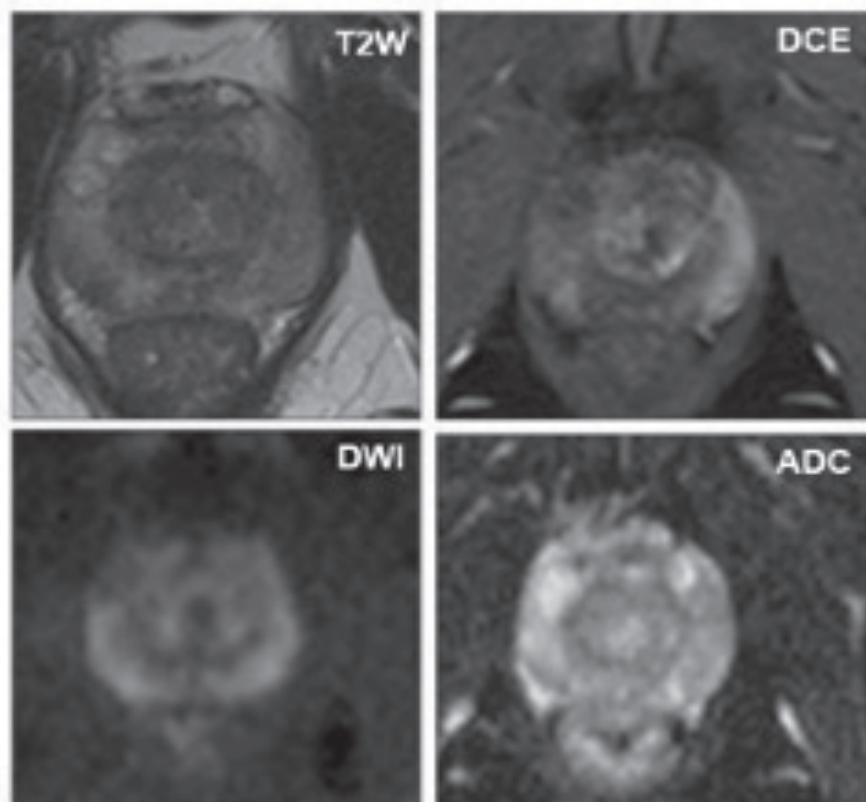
mpMRI images of the prostate. (Clinically significant right PZ tumour. T2-weighted sequence [T2W] demonstrating the general anatomy of the gland and tumour; top left panel. DCE sequence demonstrating the increased tumour vasculature; top right panel. DWI and apparent diffusion coefficient [ADC] sequences demonstrating increased tumour tissue density; bottom).
